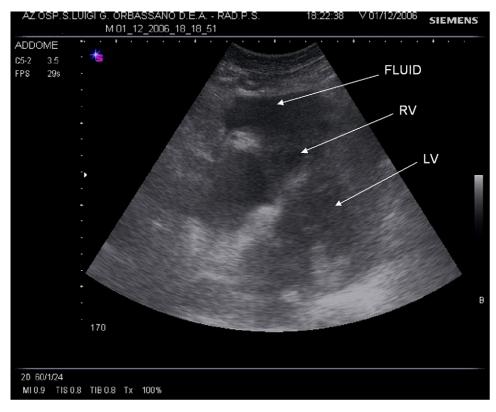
Sonographic image of the heart of a patient with tamponade as a cause of cardiac arrest. This subxiphoid view, performed during pausing of chest compression and checking carotid pulse, shows some pericardial effusion (upper white arrow). In real time, the mechanical collapse of the right ventricle was clearly visible. RV indicates right ventricle; LV, left ventricle.
